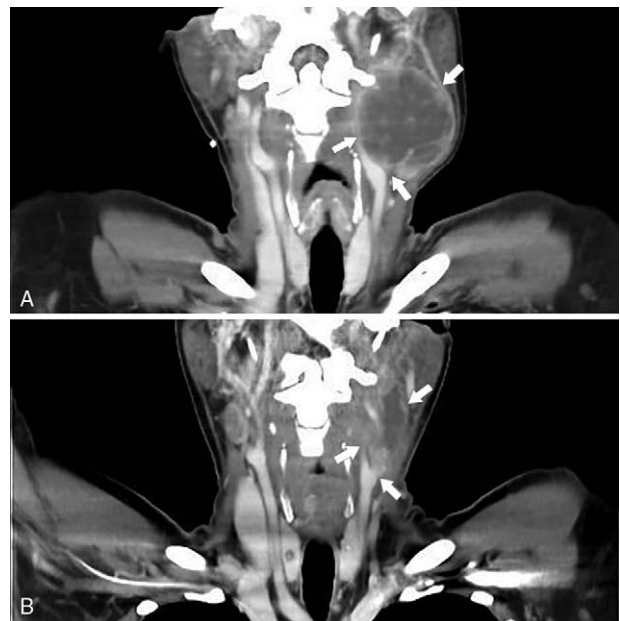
CT scans showing the left cervical lymph node which compressed the carotid sinus (A) before and (B) after chemotherapy. CT=computed tomography.
